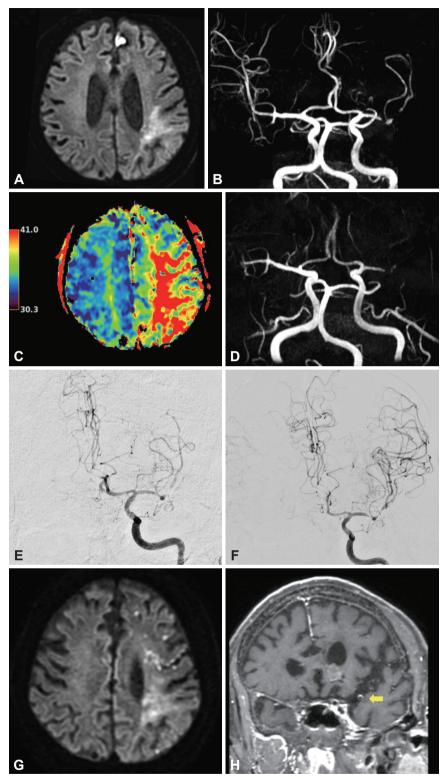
Brain imaging of a patient with acute ischemic stroke that occurred after long-term lorlatinib use. A: Brain magnetic resonance (MR) imaging indicating acute cerebral infarction in the left middle cerebral artery (MCA) territory and a left frontal metastatic lesion. B: MR angiography revealing severe stenosis in the left MCA. C: Perfusion MR imaging revealing delayed cerebral perfusion in the left MCA territory. D: Follow-up MR angiography after symptom aggravation indicating near occlusion of the left MCA. E: Cerebral angiography demonstrating reduced blood flow in the left MCA territory (mTICl 2a). F: Improvement in blood flow (mTICl 2b) after mechanical thrombectomy. G: Diffusion-weighted image after mechanical thrombectomy revealing newly developed multifocal cerebral infarction in the left MCA territory. H: Atherosclerotic plaque (arrow) of the left MCA on vessel wall MR imaging.
